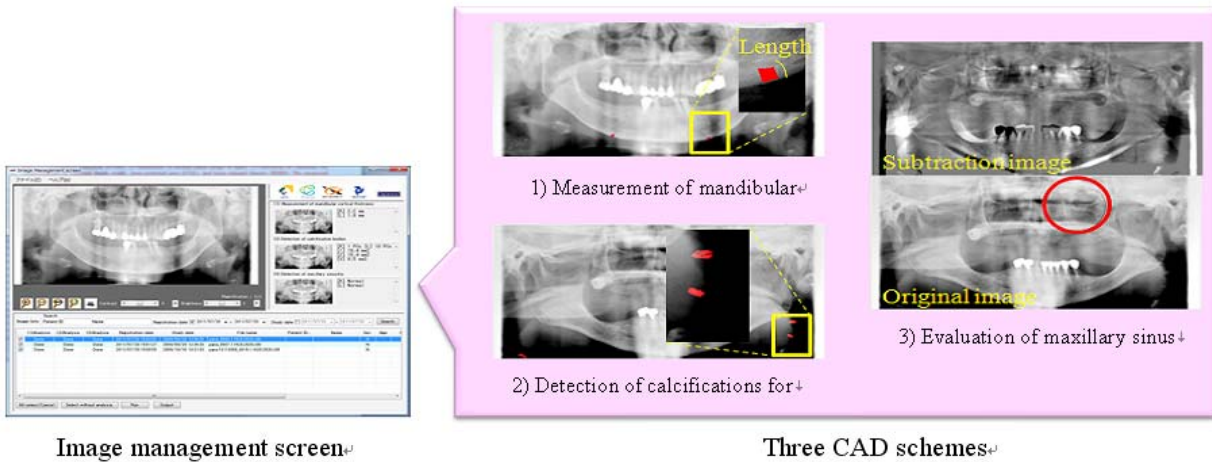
Overview of the proposed CAD for panoramic radiography
